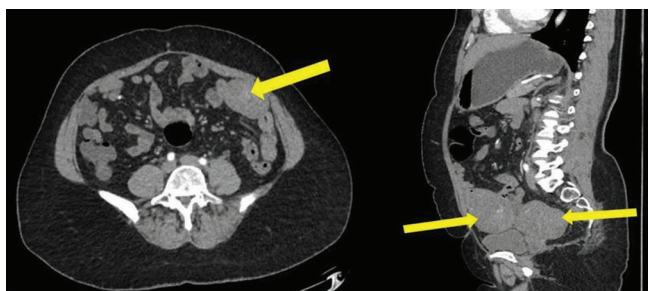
Axial CT in the arterial phase shows a well-defined, heterogeneously enhancing soft tissue lesion in left lower abdomen. The lesion has smooth margins and no internal cystic areas or calcification. There is no surrounding fat stranding or desmoplastic reaction. Figure-2: Two well defined heterogeneously enhancing mass lesions are seen in the pelvis on sagittal arterial phase CT. Fat planes with the urinary bladder are maintained.
